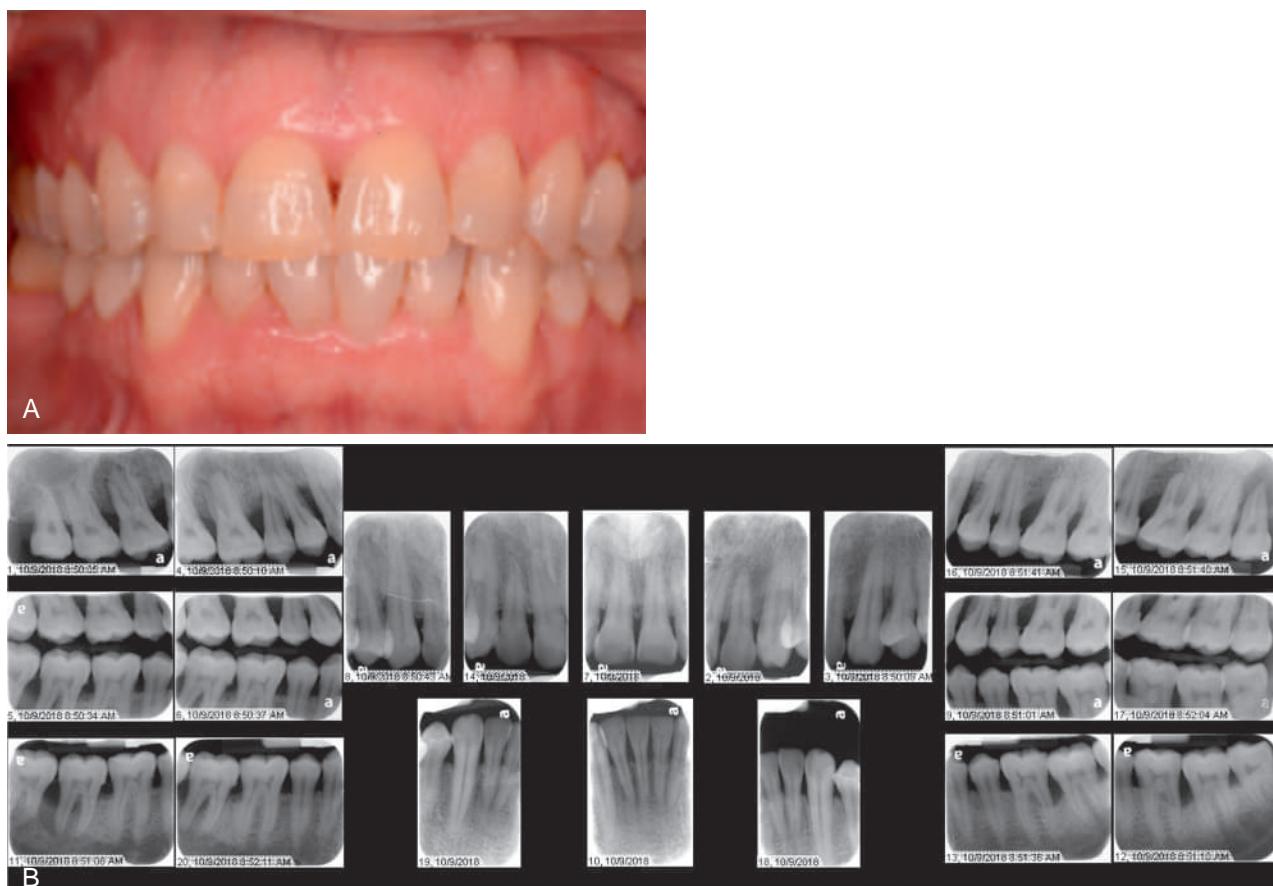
(A) Clinical presentation of stage III periodontitis. (B) Radiographic presentation of stage III periodontitis.
